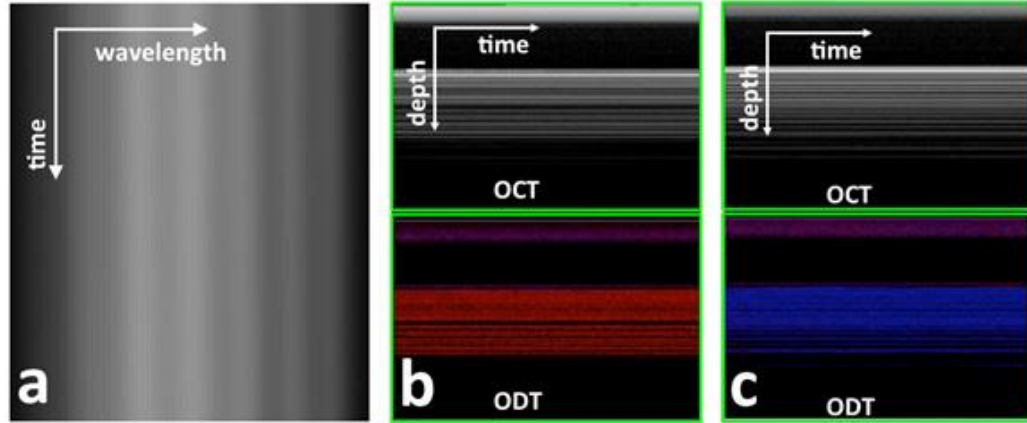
(a) A frame of interferometric spectrum when force is applied to the probe; (b) structural OCT image (upper) and Doppler OCT image (lower) during compression of sample by qOCE probe; (c) structural OCT (upper) and Doppler OCT images (lower) when the compression is released.
